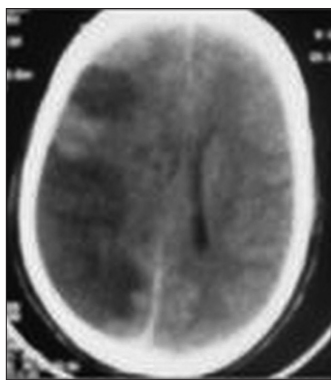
CT head showing hypodensity in the right middle cerebral artery territory suggesting infarction
